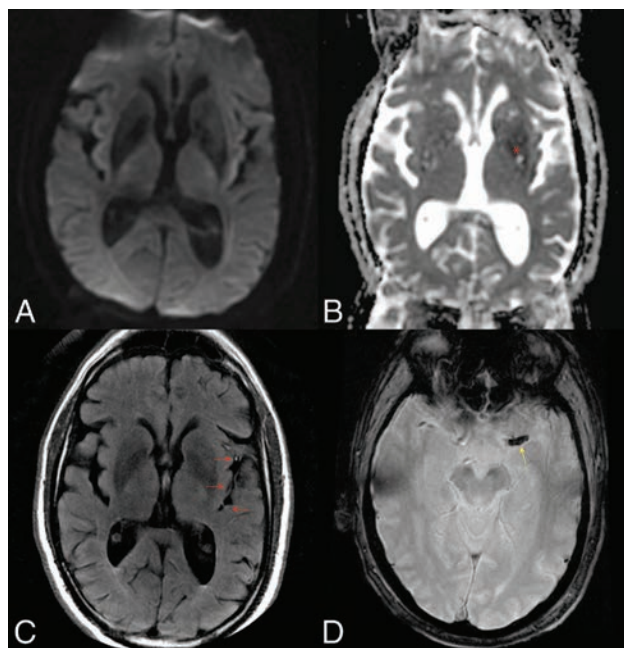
Baseline MR imaging. A 69-year-old patient was admitted for a left middle cerebral artery ischemic stroke, with an NIHSS score of 18 at 3 hours after symptom onset. The DWI and ADC maps (A and B, red asterisk) showed a limited infarct core of the lenticular nucleus, negative findings on FLAIR, and a clot in the M1 segment of the artery with susceptibility artifacts on the T2 echo gradient (D, yellow arrow) acquisition. Some evidence of slow flow was also visible on FLAIR as sulcal hypersignals (C, red arrows).
